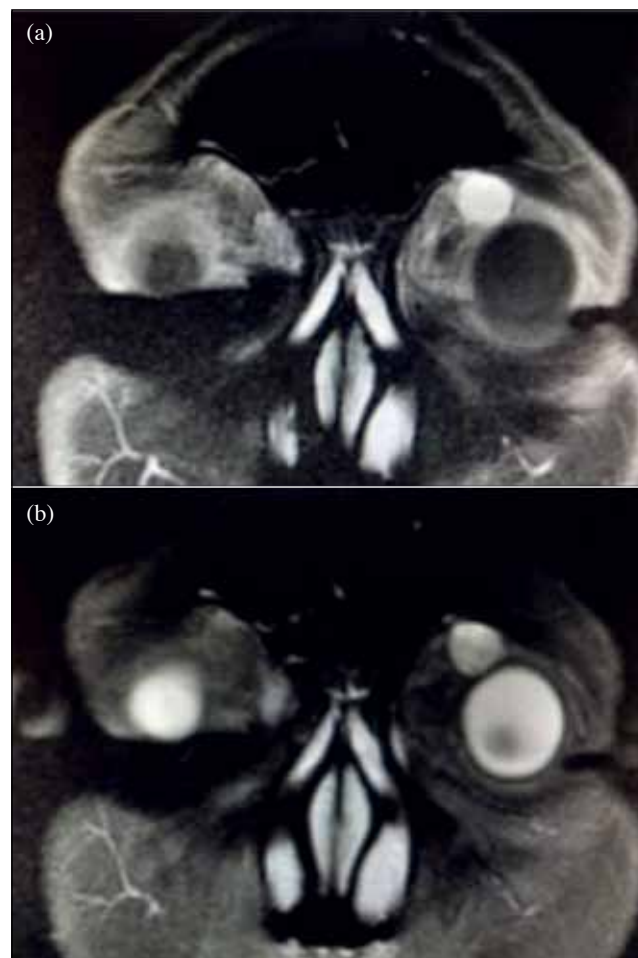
(a) T1-weighted and (b) T2-weighted contrast-enhanced magnetic resonance imaging of the orbits showing a T1-hypointense and T2-hyperintense, avidly enhancing lesion, with no calcification or soft tissue or osseous invasion. There are no internal T1-hyperintense signals or fluid levels.
